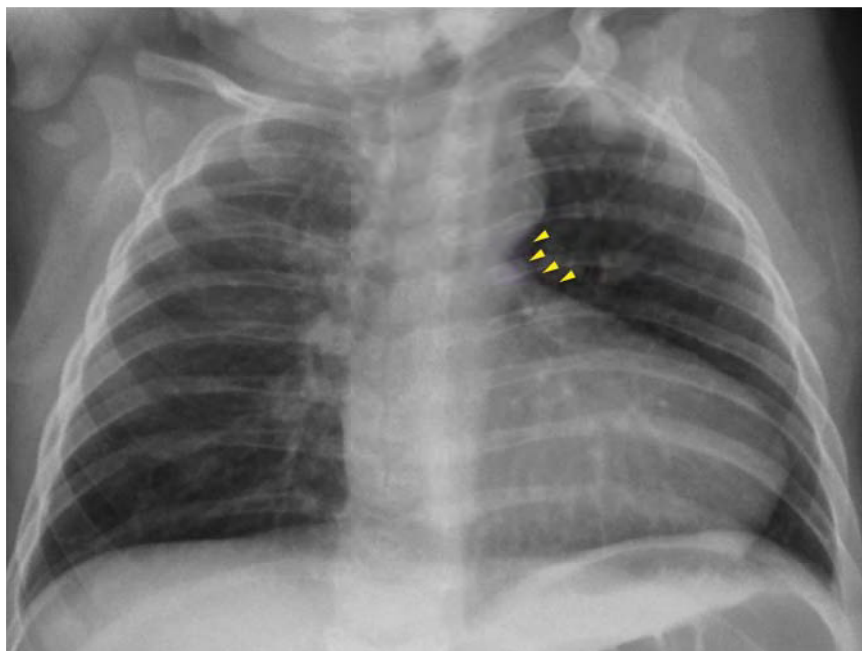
Chest radiograph of a neonate with pulmonary atresia with ventricular septal defect showing a classic “boot-shaped heart.” Concavity (yellow arrow heads) in left border of cardiac silhouette is due to the absence of the central pulmonary artery. The cardiac apex is lifted off the diaphragm because of right ventricular hypertrophy. Note the absence of a thymic shadow raising suspicion of 22q11 deletion.
